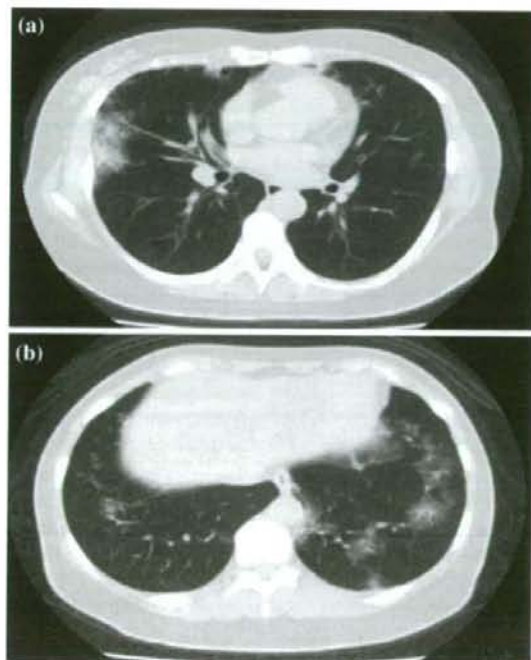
Chest CT scans on admission demonstrating ground-glass opacification throughout the right middle (a) and left lower (b) lobes
